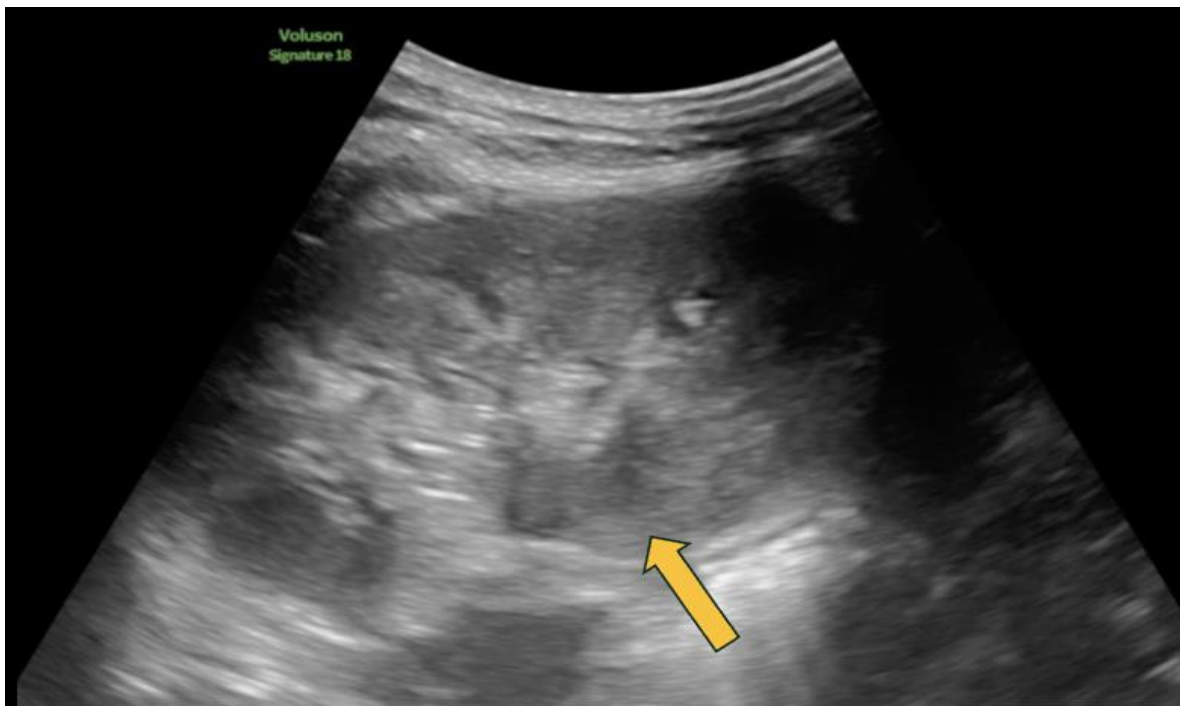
Ultrasonography Showing Normal Cortical Thickness and No Evidence of Hydronephrosis/Papillary Necrosis.
